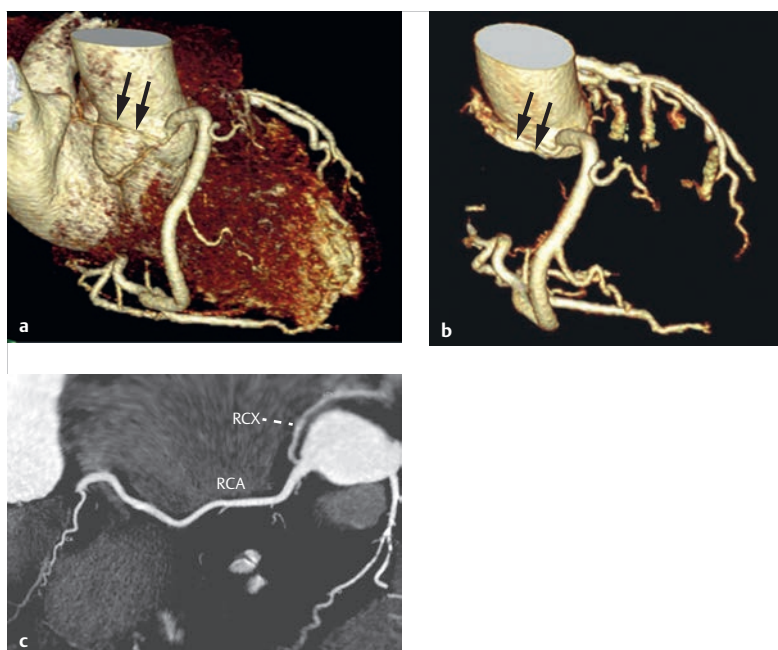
Isolated atypical origin of the circumflex branch from the right coronary artery. Various CT reconstructions from a CT coronary angiogram in a 67-year-old male patient. The arrows in a and b indicate the origin of the circumflex branch. RCA = right coronary artery; RCX = ramus circumflexus (circumflex branch)
